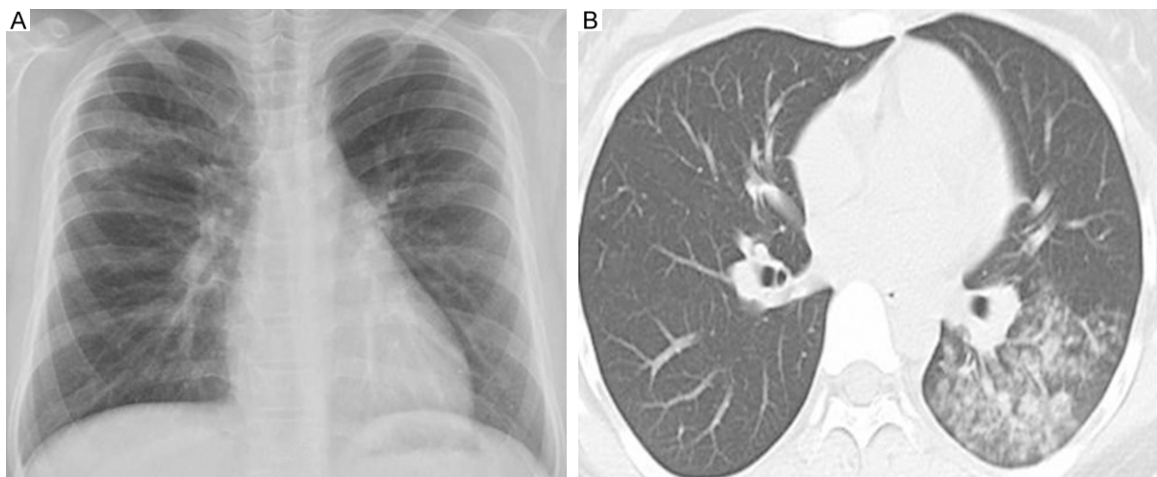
Typical of the imaging appearances of adenovirus pneumonia. A. Ground-grass opacity in X-ray. B. Multifocal consolidation in CT.
